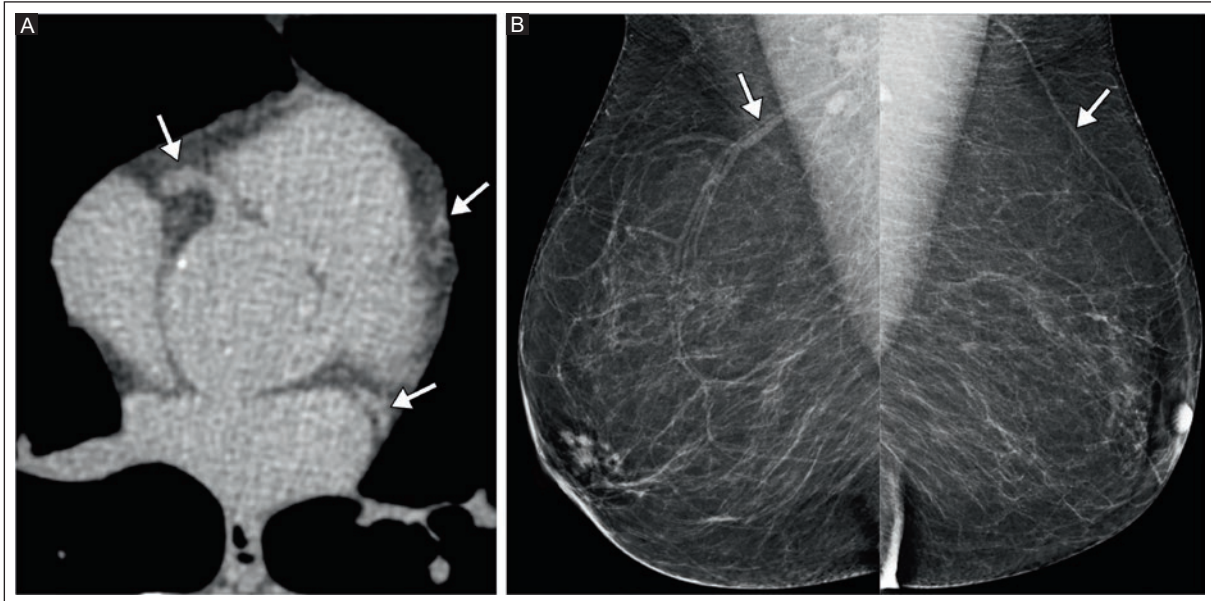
A 66-year-old asymptomatic woman. A: coronary CT artery calcium scan, axial view, without calcifications (arrows), AS was 0. B: digital mammography in MLO projection of both breasts shows bilateral breast arteries without calcifications (arrows). The BAC score was 0, and the BAC category was 0 (absence).
